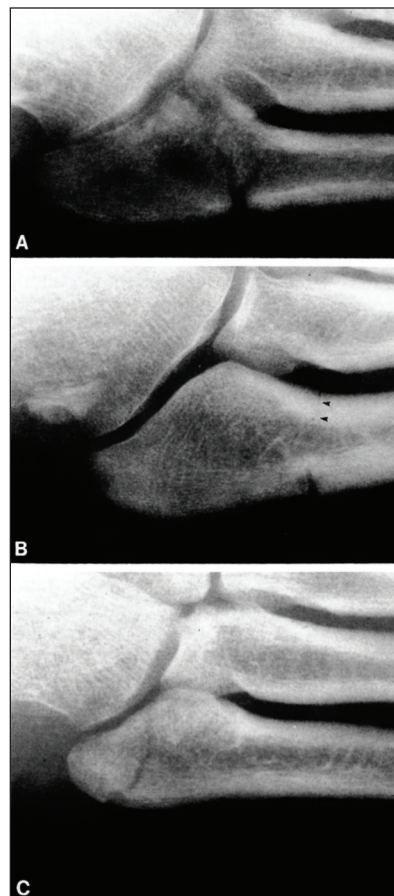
X-rays of the three fracture types of the proximal fifth metatarsal: A) metaphyseal-diaphyseal (Jones fracture), B) diaphyseal shaft fracture, C) proximal avulsion fracture.¹⁴
